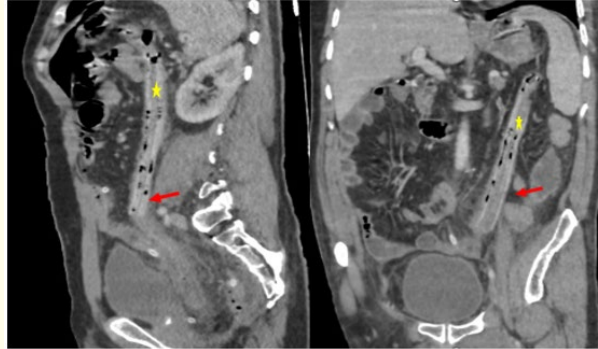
(A, B) Computed tomography (coronal and sagittal sections) demonstrating the Delbet blade (asterix) intraluminally in its entire length, trapped in the descending colon (arrows).
